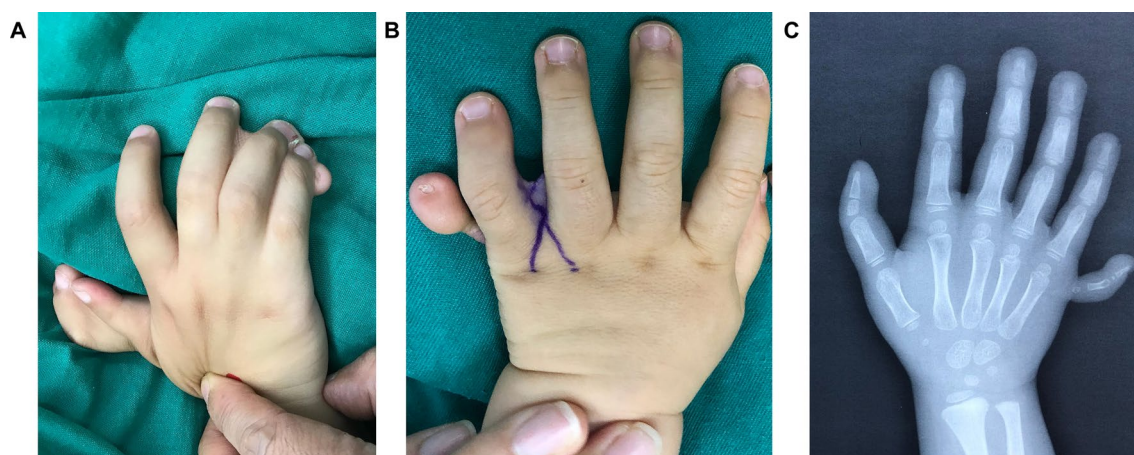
Clinical and radiographic examples of Type 0 ulnar polydactyly. (A) Preoperative view of a Type 0a case (nubbin), also presenting with syndactyly and radial polydactyly. (B) Preoperative view of a Type 0b case (floating digit connected by a skin bridge). (C) X-ray of a Type 0c case, showing a hypoplastic little finger without a skeletal connection to the hand
